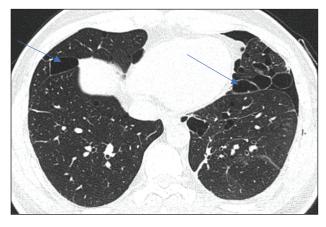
CT thorax suggestive of cysts, predominantly at fissures and para mediastinum in both lungs.
